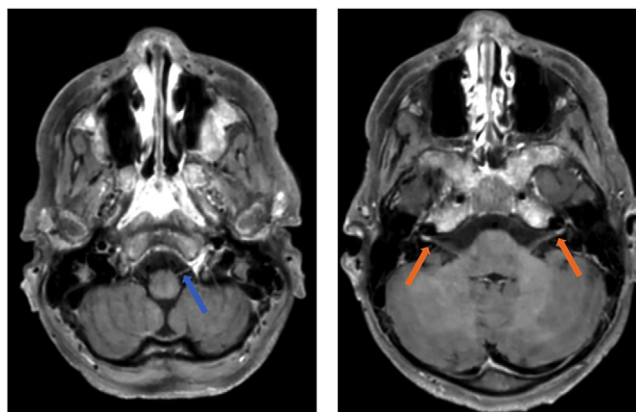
Axial slices of brain magnetic resonance imagery (MRI) (T1w TSE SPIR images). Cranial nerves enhancement upon gadolinium injection is shown: blue arrow pointing the hypoglossal nerve (left panel) and the two red arrows pointing the two facial nerves (right panel)
